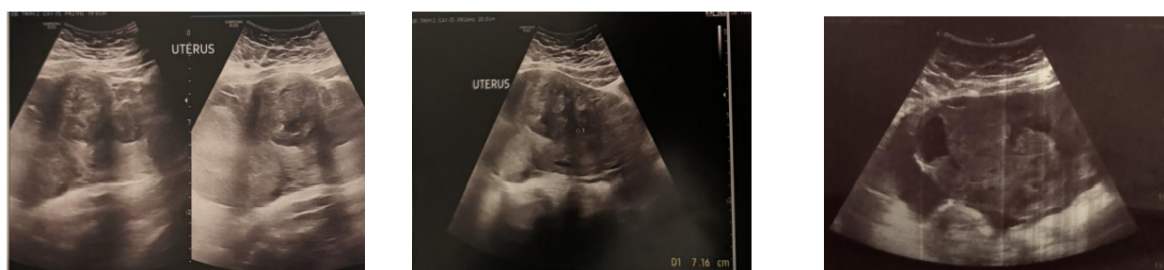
Ultrasound image showing the extra-uterine fetus in a left lateral and supra-uterine position.
